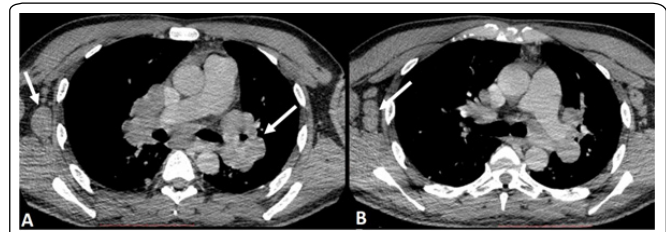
Chest CT acquisition after iodinate contrast administration at the axial plane (A, B), depicting several bilateral mediastinal, pulmonary hilar and axillary lymphadenopathies (arrows).
